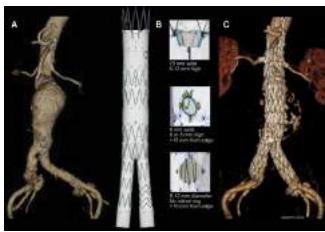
Fenestrated graft CT scan<sup>6</sup>
